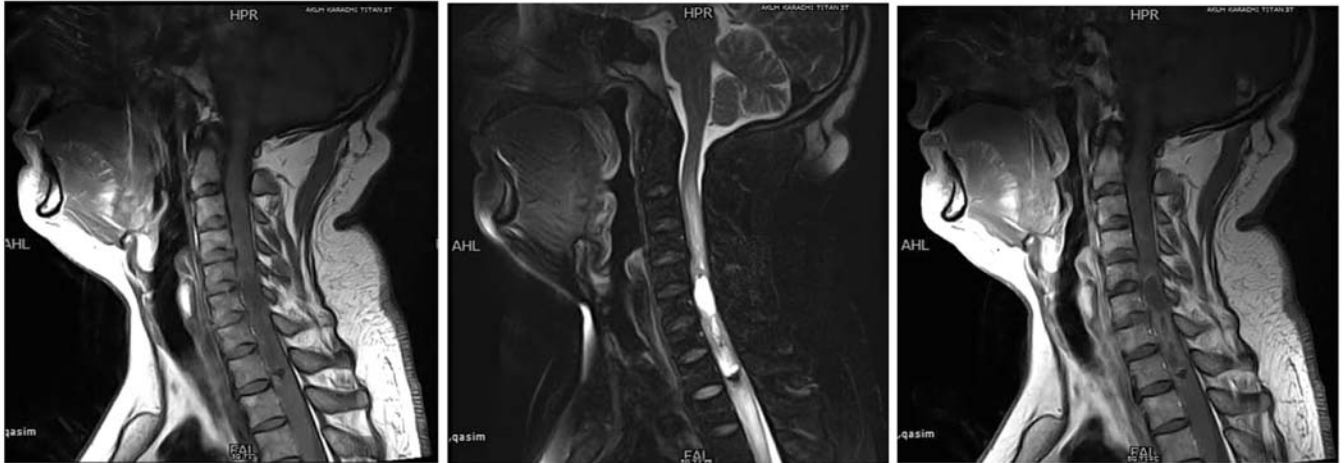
a) MRI cervical T1WI spine mid-sagittal sections showing C5-T1 iso-intense lesion; b) T2WI (fat-suppressed) of the same patient showing hyper-intense lesion associated with syrinx; c) T1WI with contrast showing heterogeneous contrast enhancement.
